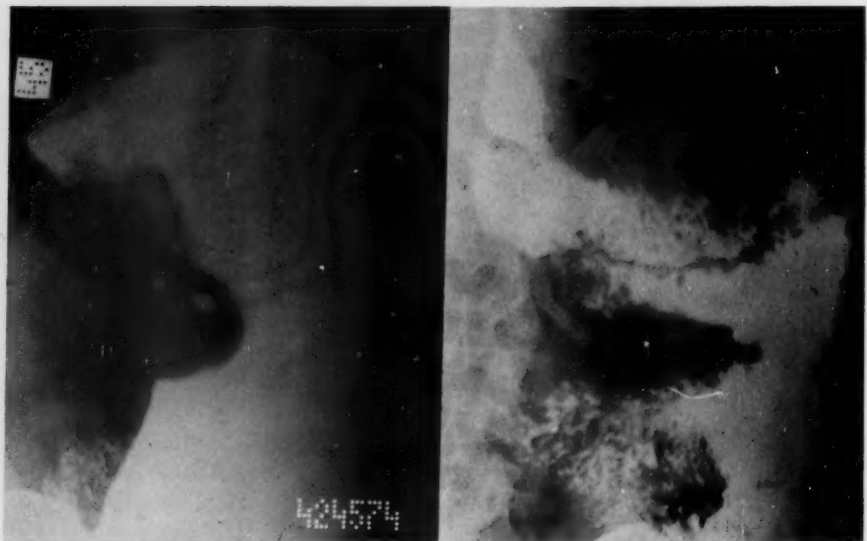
B.—Case 2, R. B.: Roentgenologic examination, June 8, 1938, demonstrates the appearance of the neoplasm shown in Figure 10 A, with the ulcer crater at the superior aspect. Roentgenologic examination, December 28, 1938, demonstrates the esophagojejunal anastomosis following the total gastrectomy.
